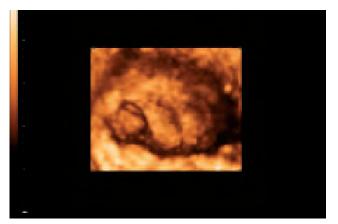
A 3D ultrasound of preovulatory cumulus oophorus
